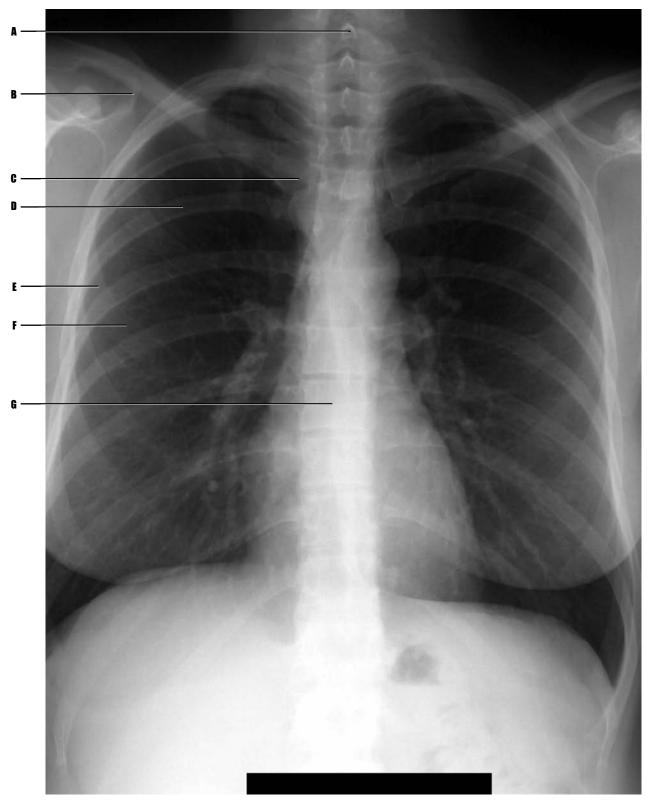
Adult patient, plain film radiograph, posteroanterior view of chest.
